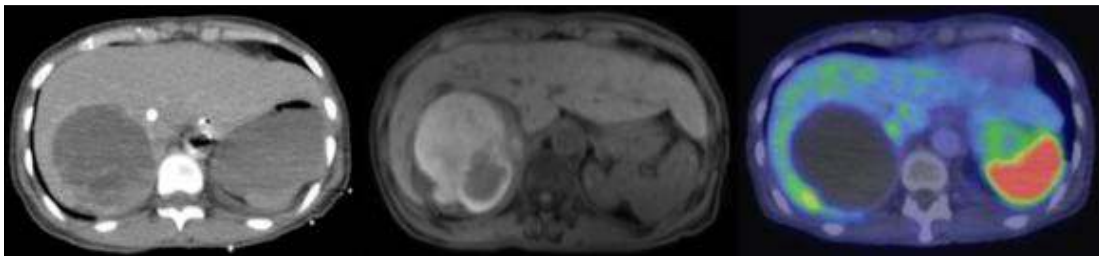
CT scan vs MRI (T1) vs 68 Gallium Dota-peptide scan of the right abdominal mass demonstrating clear delineation of the adrenal from liver on MRI but not on CT, functional scan showed large cystic adrenal mass
